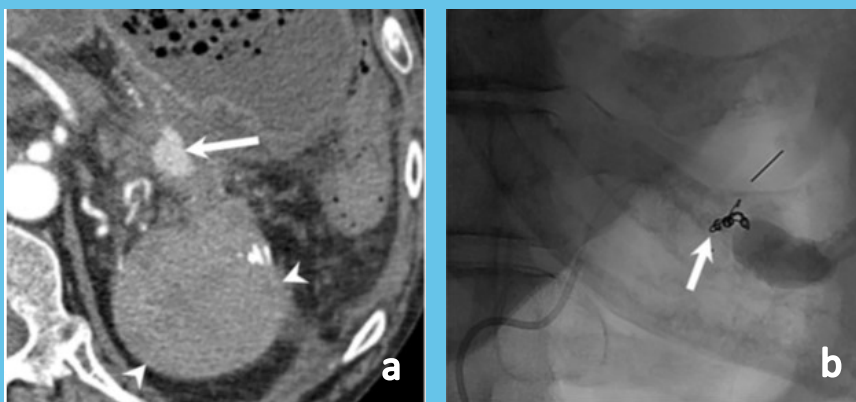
(a) CT angiogram demonstrates active bleeding from a gastric artery pseudoaneurysm with an adjacent large hematoma. (b) Angiography and treatment performed by interventional radiology shows coil embolization of the site of hemorrhage.
